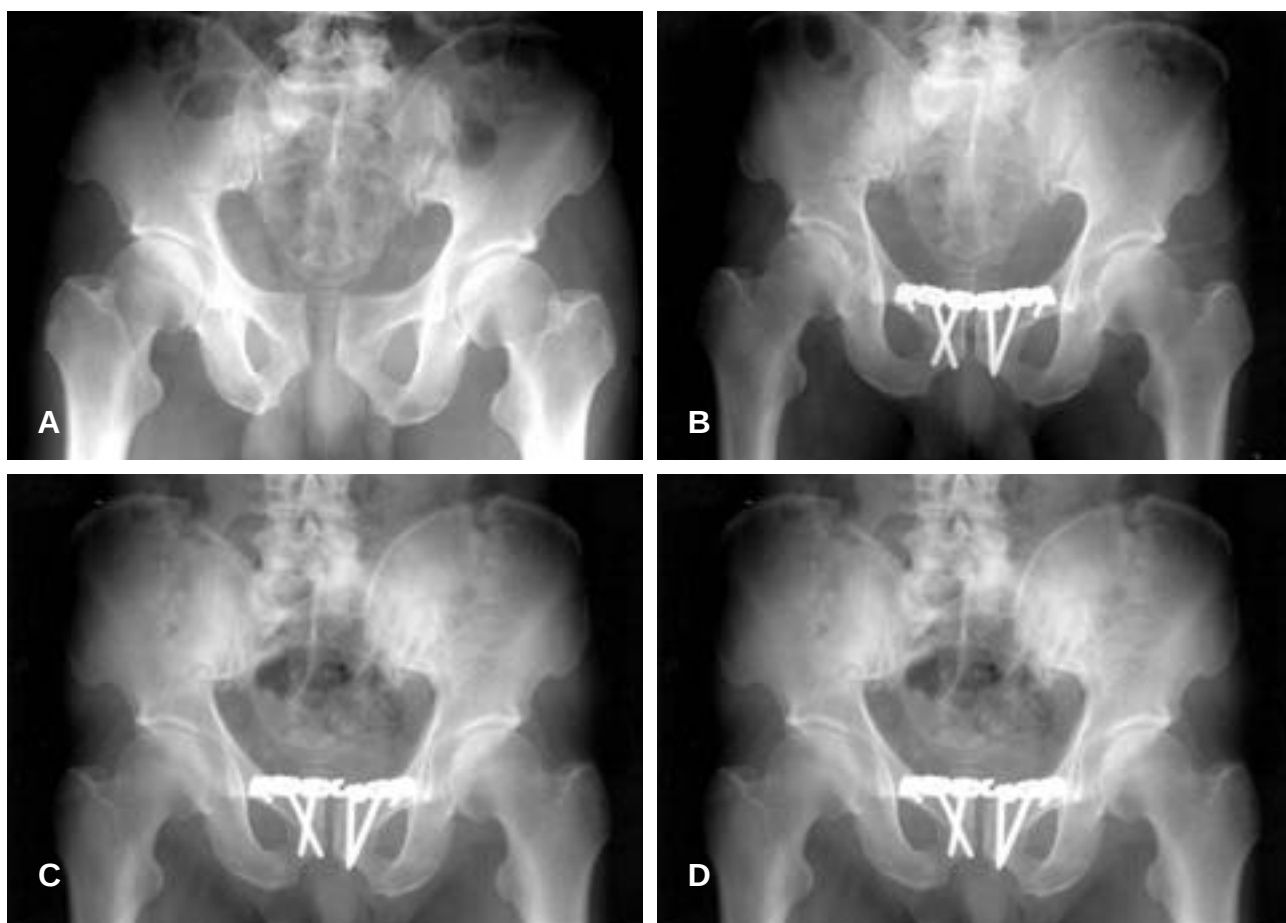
Radiographs of a 51-year-old-man. (A) His pelvic injuries include a wide symphyseal separation. (B) A satisfactory reduction is achieved by open reduction and internal fixation of the symphyseal separation. (C) 1 year follow-up radiographic reveals fatigue fracture of the plate. (D) Follow up radiograph shows healed symphyseal separation after removal of the plate.
